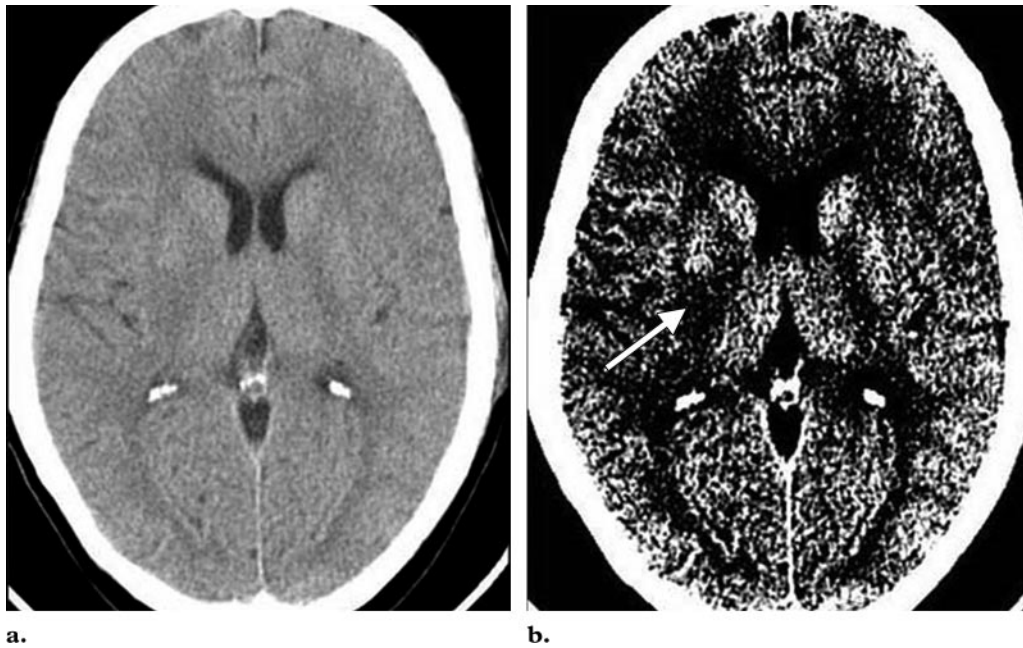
Axial unenhanced CT images, obtained in a 45-year-old man 2 hours after the onset of left hemiparesis, show obscuration of the right lentiform nucleus (arrow in b). This feature is less visible with the routine brain imaging window used for a (window width, 80 HU; center, 35 HU) than with the narrower window used for b (window width, 10 HU; center, 28 HU).
